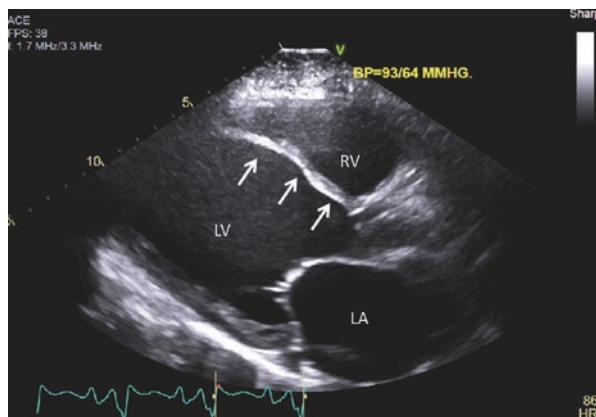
Parasternal long axis showing cardiac sarcoid. Note dilation of the LV with septal thinning (arrows). LA left atrium, LV left ventricle, RV right ventricle
